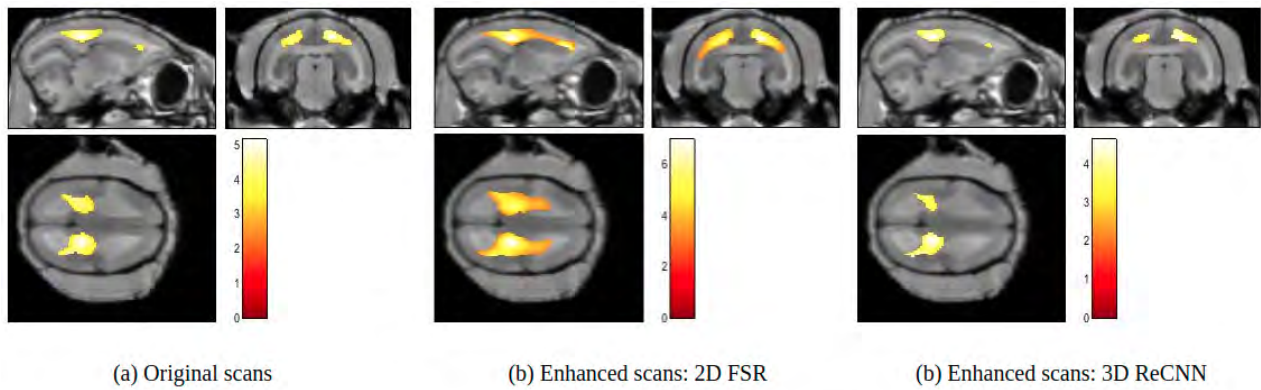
VBM analysis of WM increase for 185 MRI scans from 42 marmosets with an age range of 2.5 to 14.7 years using smwWM segmentation from (a) original scans, (b) enhanced scans by 2D FSR and (c) enhanced scans by 3D ReCNN. This figure shows the pixels of global maximum for each case. The color bar ranges from least (red) to most significant (white) change.
